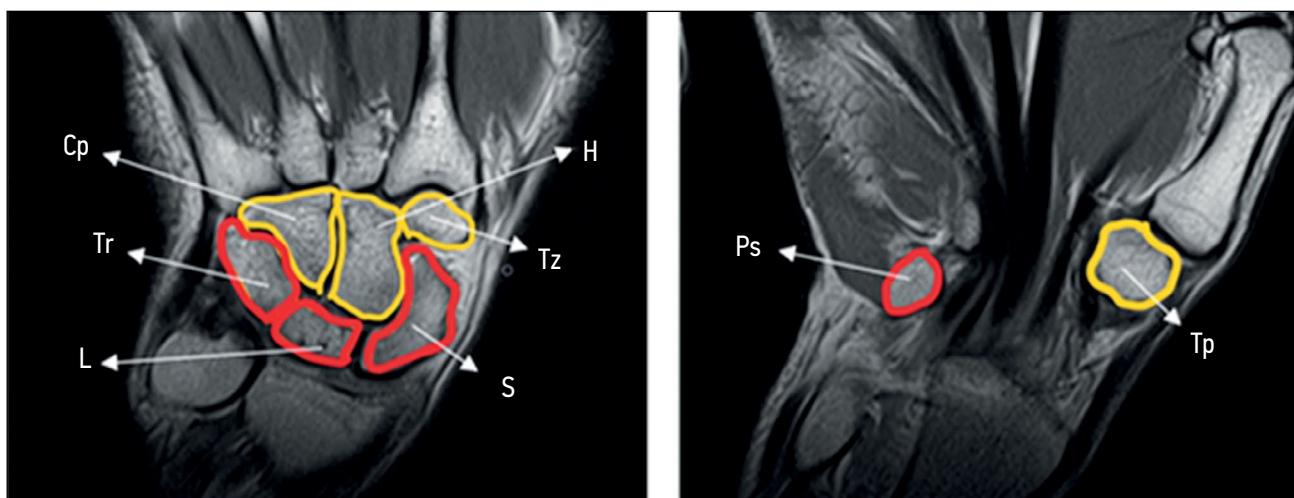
Left hand, wrist bones, and magnetic resonance imaging (T1-weighted images, coronal plane). The proximal bone row is marked in red; the distal bone row is marked in yellow. S, scaphoid bone; L, lunate bone; Tr, triquetral bone; Ps, pisiform bone; Tp, trapezium bone; Tz, trapezoid bone; H, hamatum, Cp, capitate bone.
